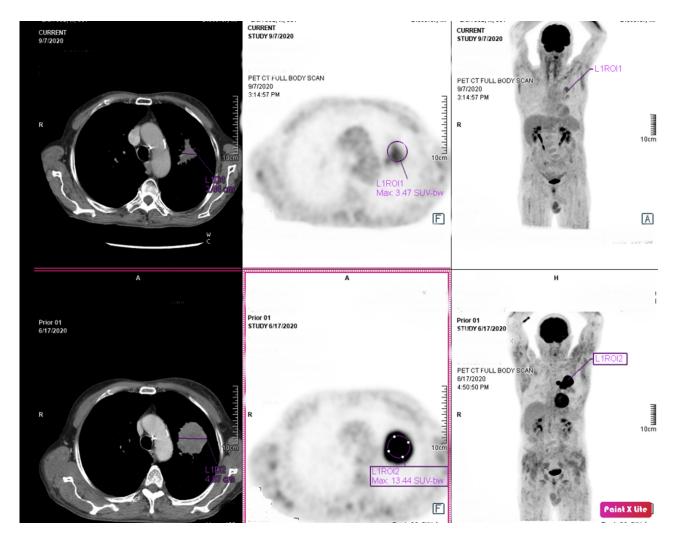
PET-CT-FDG results of the patient. (*A*) During initial diagnosis on June 2020 revealing tumor size of 4.87 cm and uptake of 13.4 HU. (*B*) Follow-up PET-CT on September 2020 after chemoradiation treatment revealing reduction in tumor size to 2.4 cm and uptake to 3.4 HU. CT, computed tomography; FDG, fluorodeoxyglucose; HU, Hounsfield unit; PET, positron emission tomography; SUV, standard uptake volume.
